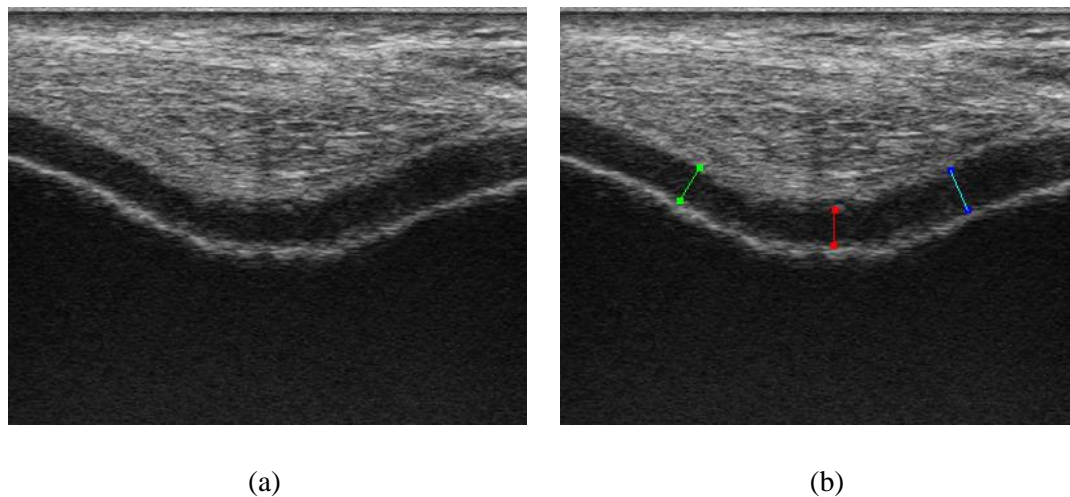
Ultrasound images of the femoral cartilage (a) with intercondylar notch (IN, red line), lateral condyle (LC, green line), and medial condyle cartilage (MC, blue line) thickness measurement (b) by an orthopaedic surgeon.
